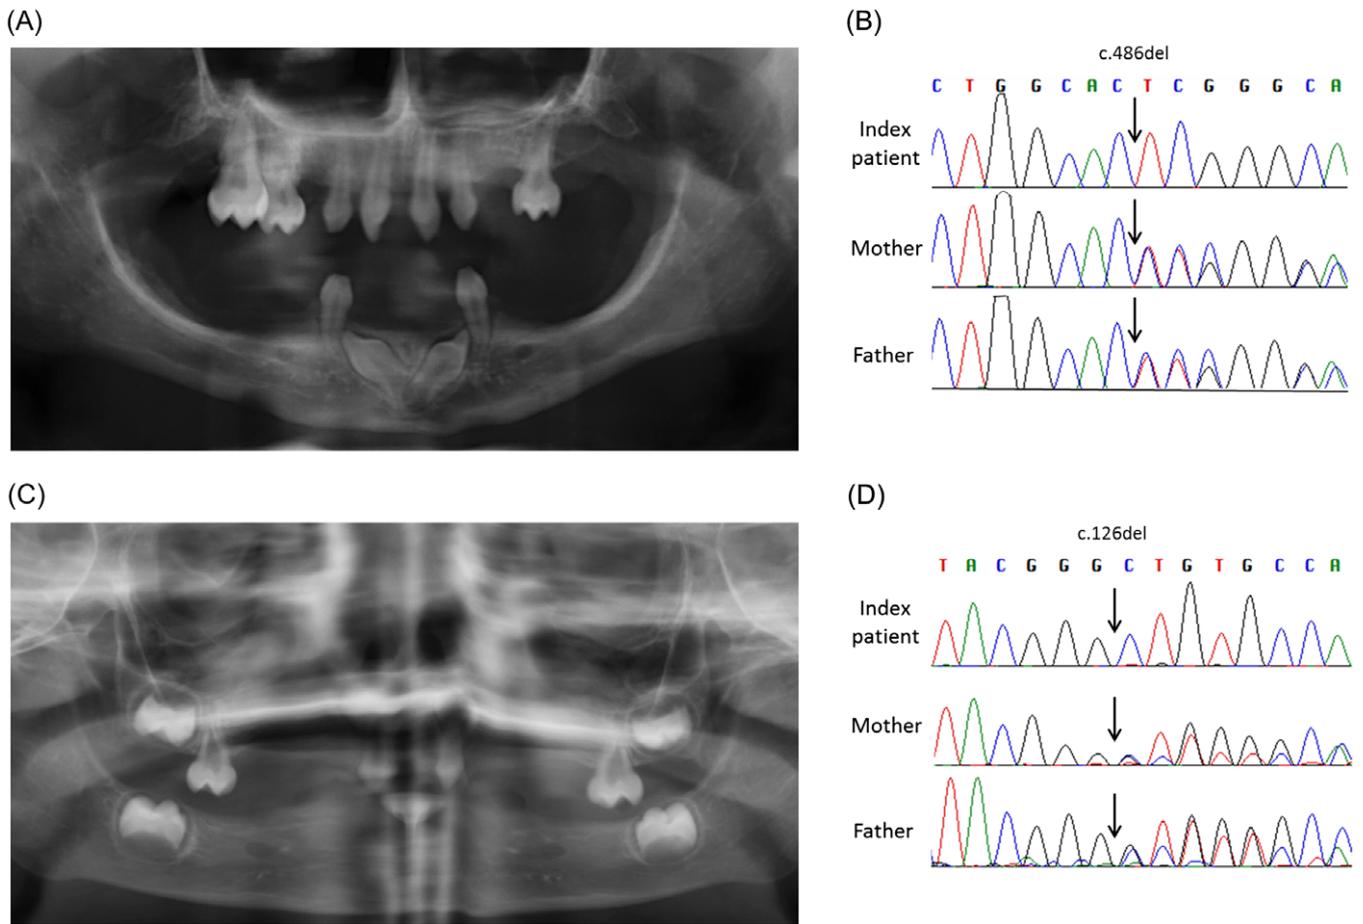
Oligodontia and genotypes of index patients #1 and #2. A, Panoramic radiograph of patient #1 at 10 years of age. B, DNA sequencing showed the *EDAR* variant c.486del. C, Panoramic radiograph of patient #2 at the age of 3 years and D, DNA sequence chromatograms showing the *EDAR* variant c.126del [Colour figure can be viewed at wileyonlinelibrary.com]
